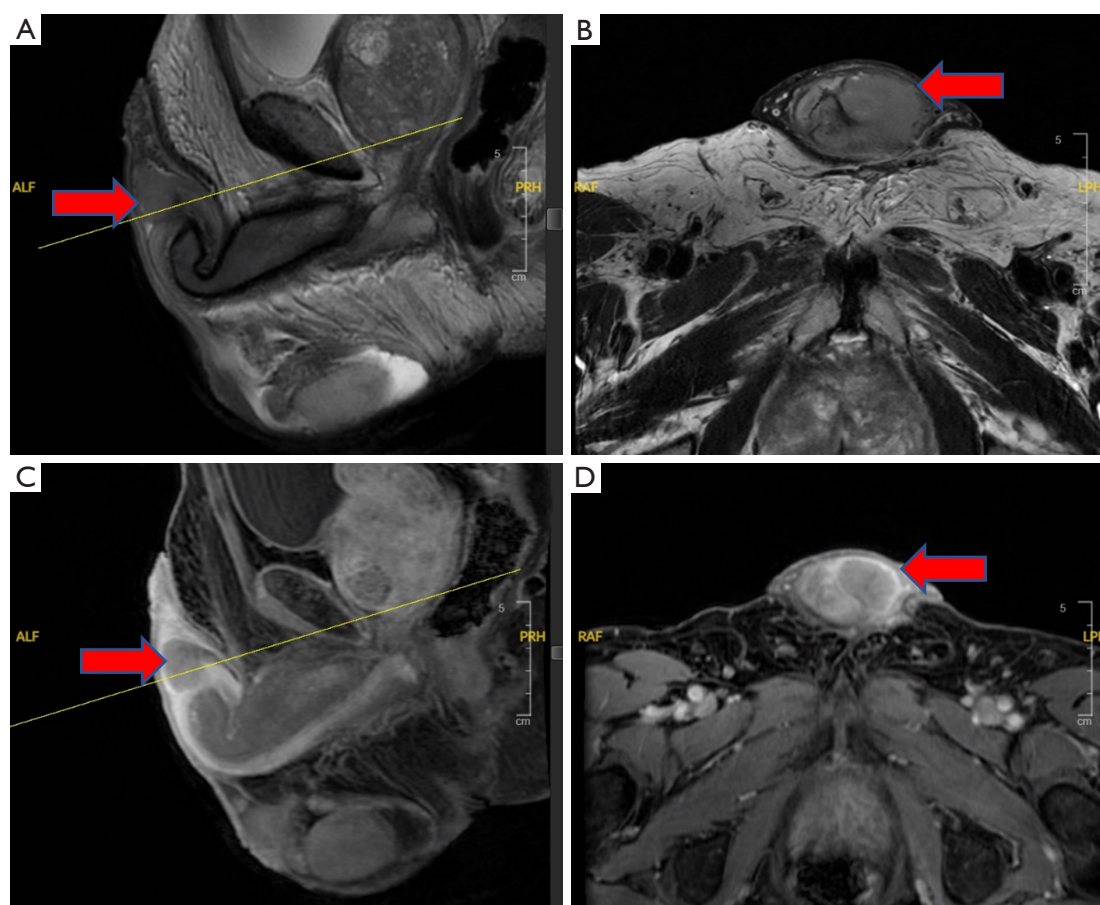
Preoperative MRI penile mass protocol including (A) sagittal T2 and (B) axial T2, and with IV contrast [(C) sagittal and (D) axial] revealed 2.9 cm × 2.0 cm solid mass along the left lateral margin of the glans, not convincingly involving distal tunica albuginea of corpora or spongiosum. No evidence of inguinal or pelvic lymphadenopathy. MRI, magnetic resonance imaging.
